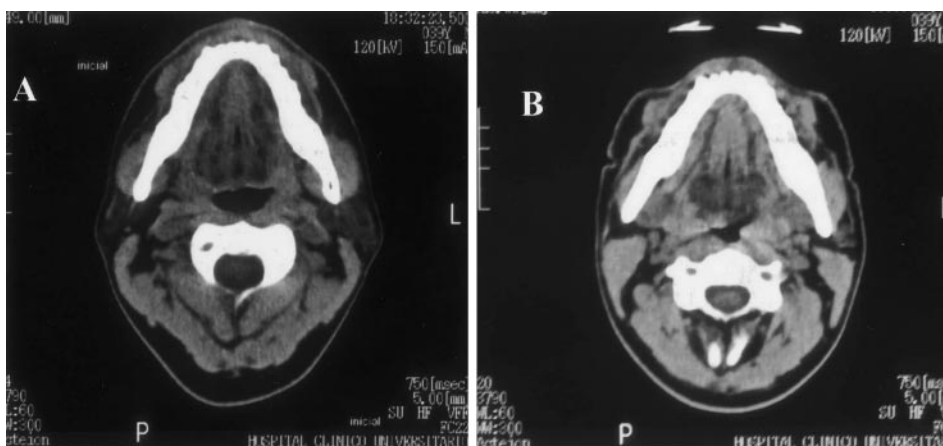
Oropharynx CT scan of a nonbulbar ALS patient with PCFMI-E > 2.7 L/s. *Left, A:* baseline. *Right, B:* during the exsufflation cycle.
